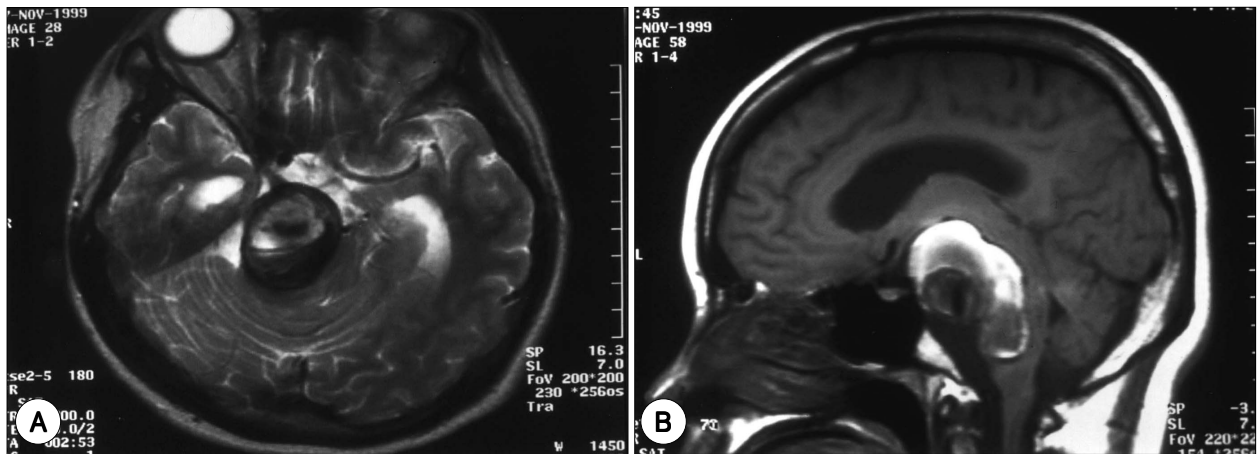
Follow-up magnetic resonance images. T₂-weighted axial image (A) and T₁-weighted sagittal image (B) showing an enlarging mass with intra-aneurysmal acute bleeding. Ventricle size is enlarged and brain stem is markedly compressed by the mass.
